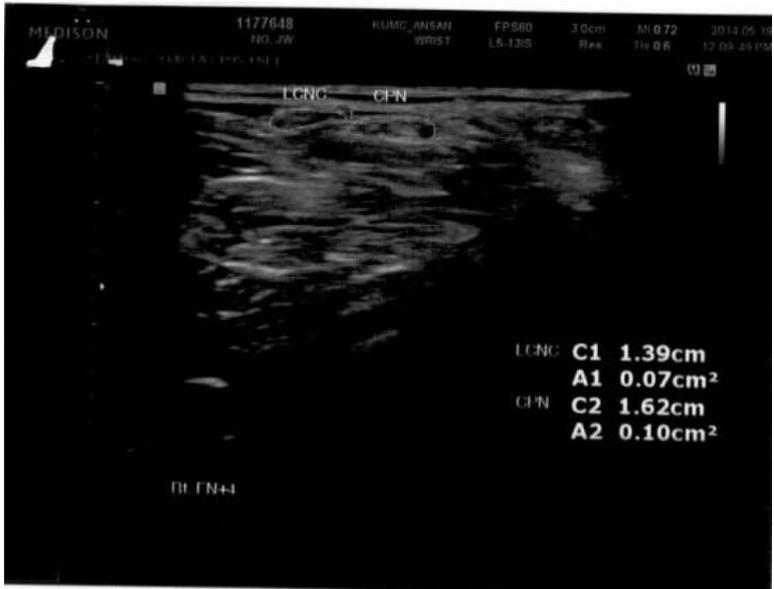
Ultrasonographic evaluation showed swelling of the right LSCN observed 4cm above the fibular neck
